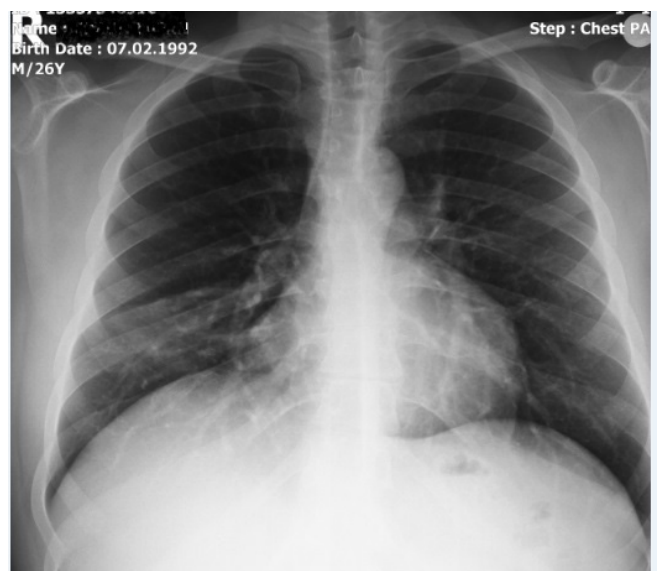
Post-treatment PA chest radiography
